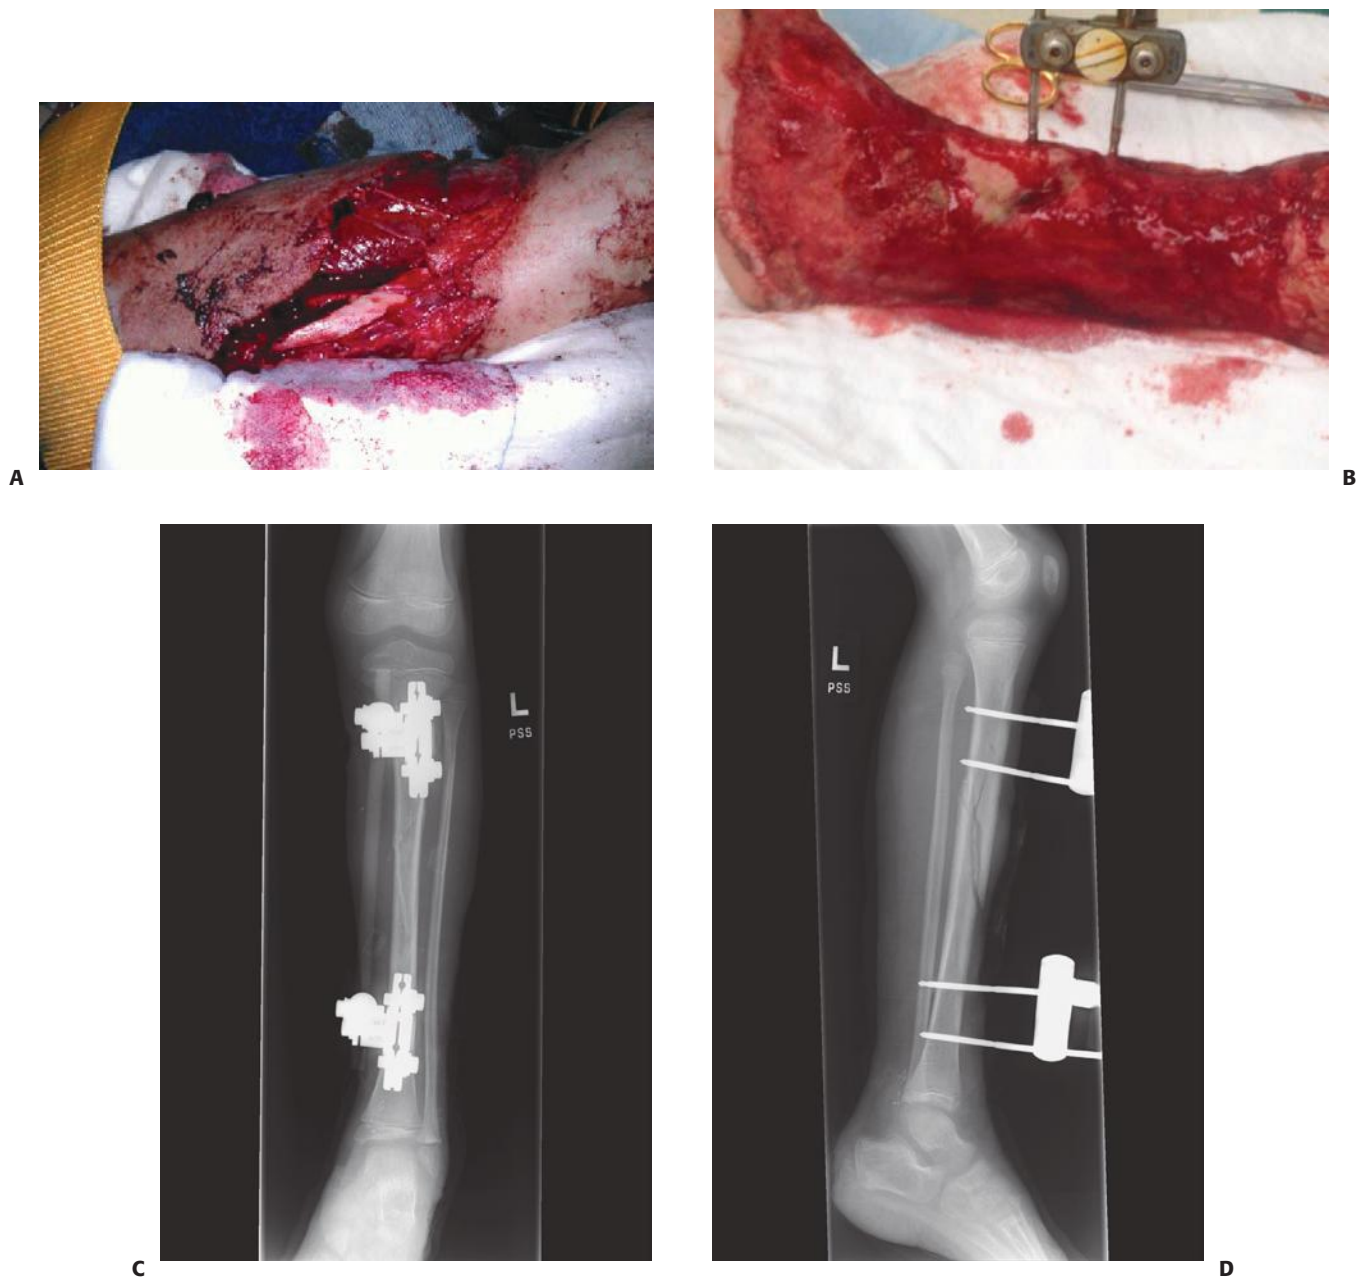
A: Grade IIIIC open tibia fracture in a 9-year-old boy hit by a bus. B: Appearance of the wound after several debridements. C, D: AP and lateral radiographs showing external fixation of the fracture. Note the vascular clips distally, where an autologous vein graft from the popliteal trifurcation was anastomosed to the posterior tibial artery.
